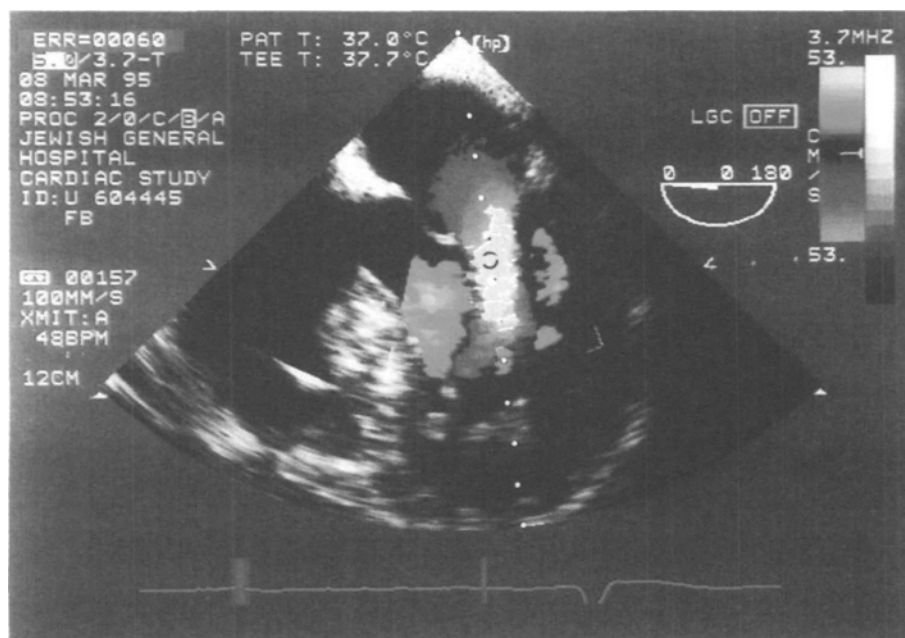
In this five chamber view, colour flow Doppler imaging of mitral diastolic inflow is used to align the pulsed wave Doppler signal. Note the change in colour as blood flow velocity increases across the mitral valve. The yellow area represents blood flow velocity which exceed the Nyquist limit.
